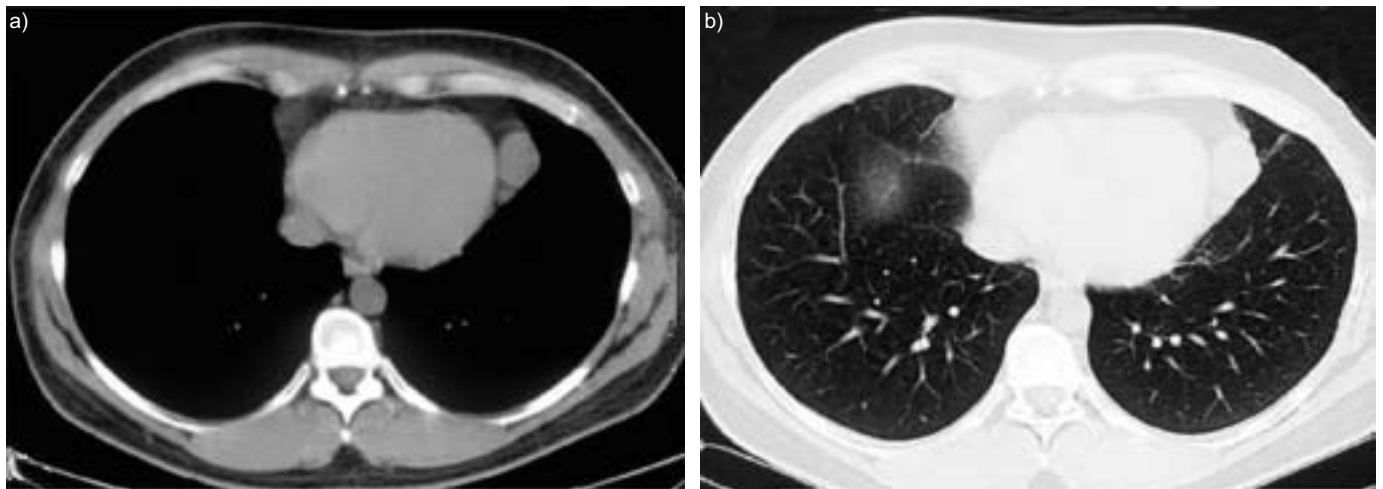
a and b) Computed tomographic scans of the chest.
